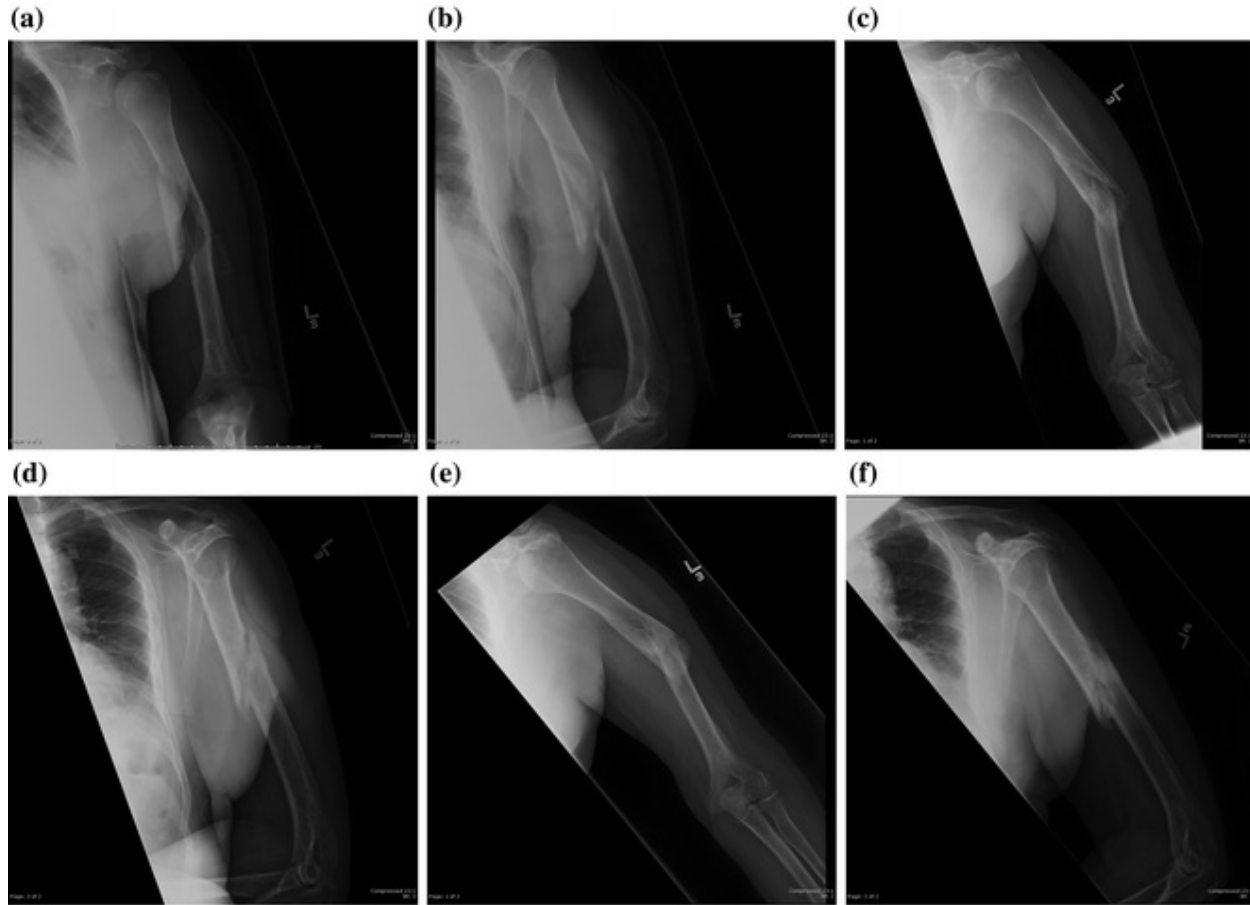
Elderly male presented with left humeral shaft fracture after low energy fall. Patient had significant medical comorbidities and decision was made to manage the patient with bracing. a, b Injury anteroposterior (AP) and lateral radiographs in brace showing excellent alignment. Patient continued with mild discomfort and radiographs showed persistent nonunion. c, d AP and lateral radiographs showing nonunion. Discussion with patient and family was to try alternative methods due to high surgical risks. Ultrasound bone stimulator (ExogenTM) was started and patient went on to heal the fracture. e, f AP and lateral radiographs 6 months later showing healed fracture
